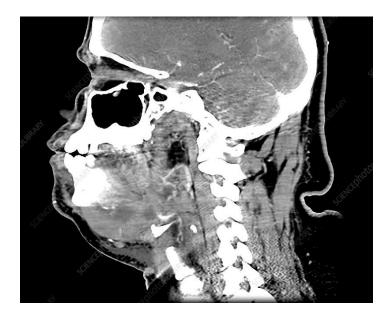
Contrast-enhanced sagittal CT shows extensive inflammatory changes in the floor of mouth that extends to the epiglottis with mild narrowing of the airway. Small fluid pockets are seen. This represents Ludwig's angina which is a severe form of cellulitis/inflammation in the floor of the mouth.
